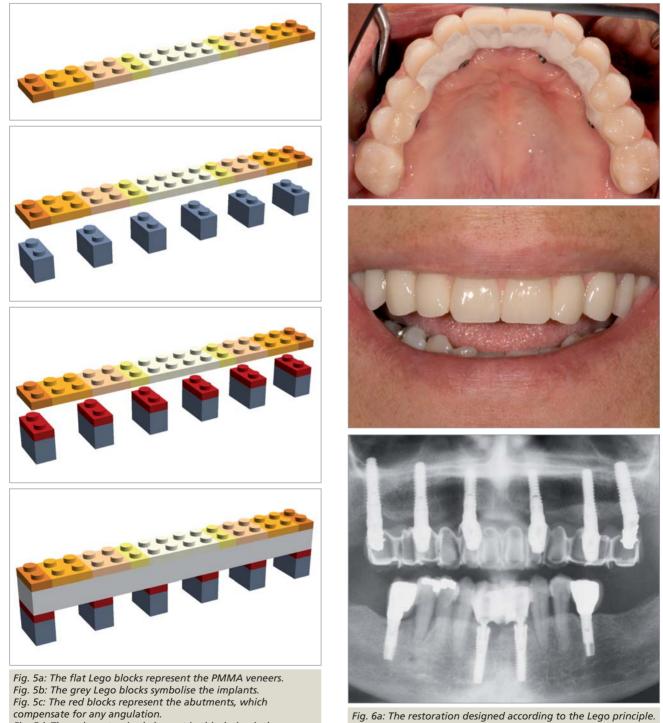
The only customised element in this design is the bridge framework (PEEK), which connects the veneers with the implants (abutments) shown here as a grey long bar. Fig. 6a: The restoration designed according to the Lego principle. Occlusal view of the screw-retained bridge. Fig. 6b: Anterior view – aesthetic natural appearance. Fig. 6c: The check X-ray after fitting the upper restoration. (Fig. 6). From the first moment onwards, the patient was satisfied with the treatment option selected. The regular recall appointments indicated that the PEEK restoration is permanently stable (Fig. 7).
